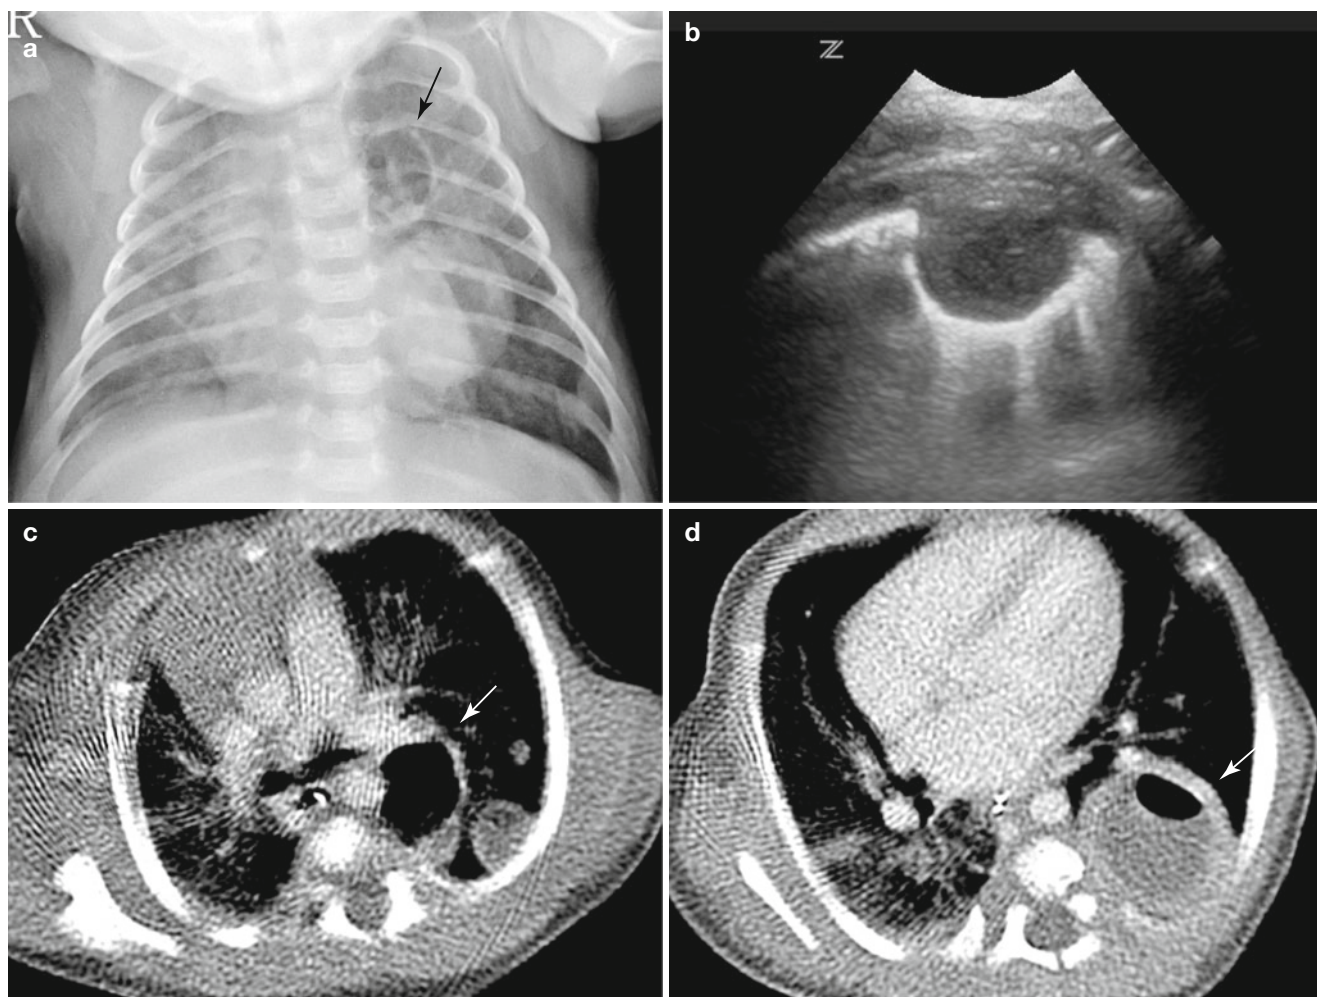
Septic pneumonia with multiple abscesses in a 32-week-gestational-age newborn. (a) Frontal radiograph obtained at 5 weeks of age reveals a large round area of consolidation in the left lower lobe and thin-walled air cyst perihilar area (*arrow*). (b) Chest ultrasonography
